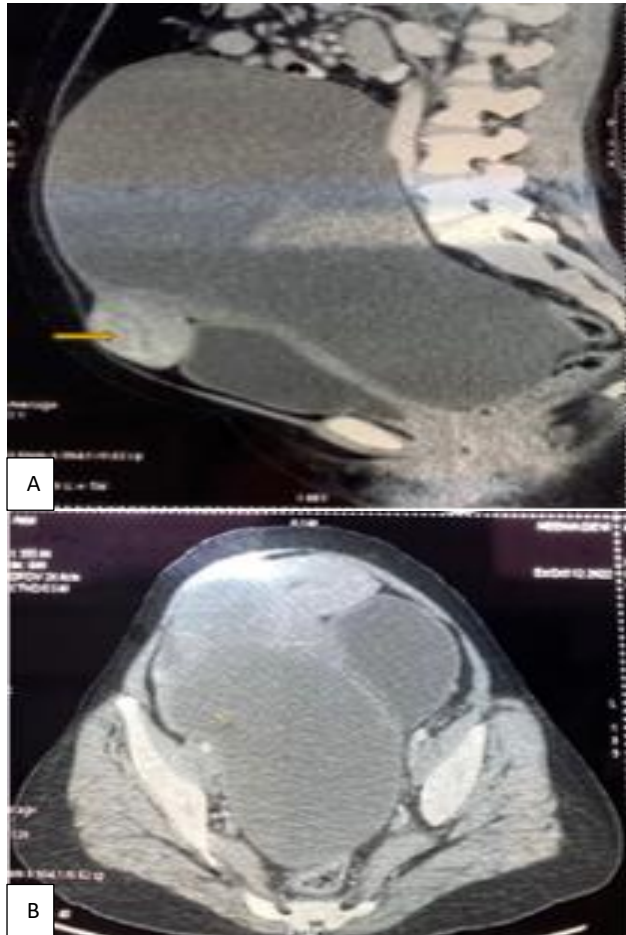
(A and B): CT of adnexal mass with uterus- longitudinal image on CT and yellow arrow shows uterus and cross-sectional view of the CT image of adnexal cyst with septation.
